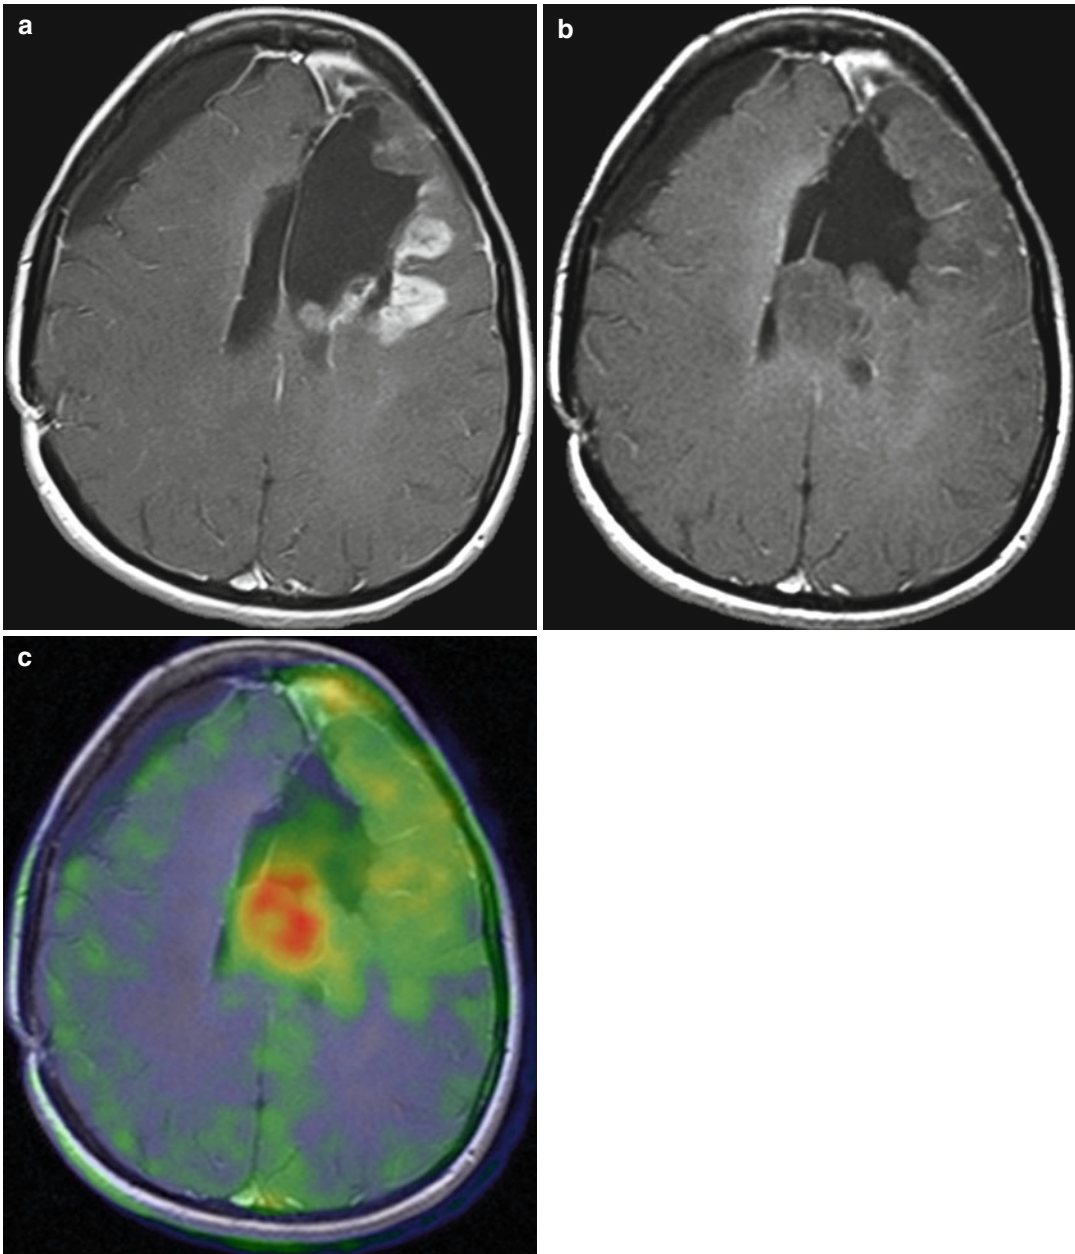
Value of PET with ^{18}F -fluoroethyltyrosine (^{18}F -FET) in recurrent glioblastoma. T1-weighted MRI (a) shows a left frontal contrast-enhancing lesion, lateral to the resection defect. After 2 months of treatment with bevacizumab, T1-weighted MRI (b) shows a marked
